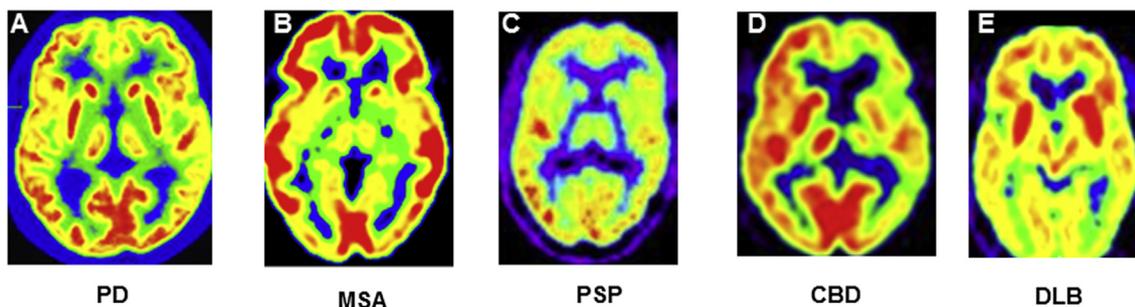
PET [ $^{18}\text{F}$ ]-FDG assessing brain glucose metabolism in degenerative parkinsonian syndromes. A: bilateral striatal hypermetabolism in Parkinson's disease (PD); B: bilateral striatal hypometabolism in multiple system atrophy (MSA); C: bilateral frontal hypometabolism in progressive supranuclear palsy (PSP); D: asymmetrical frontoparietal hypometabolism in corticobasal degeneration (CBD); E: bilateral occipital hypometabolism in dementia with Lewy bodies (DLB).
